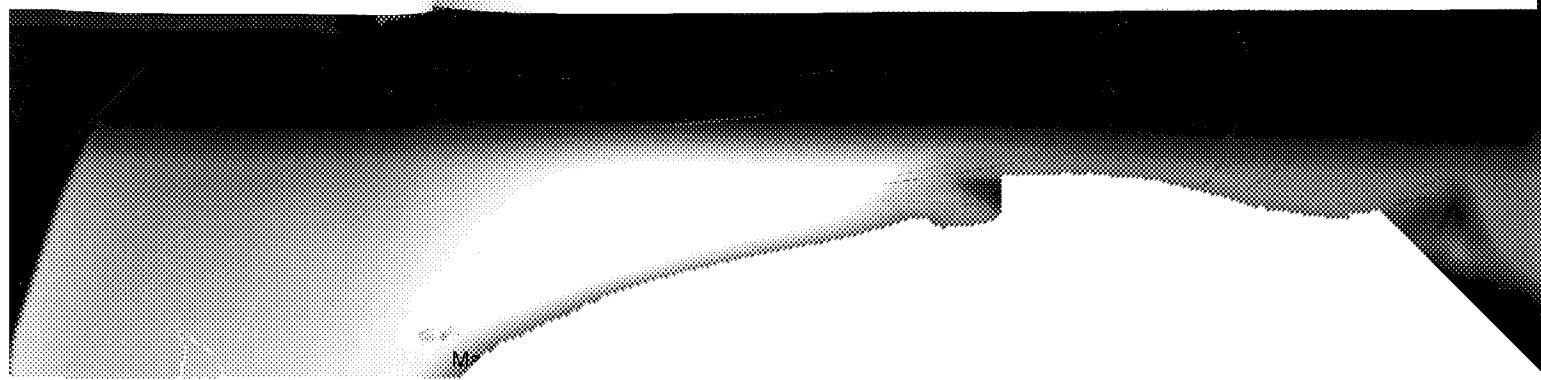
This x-ray film shows a chondroma of the rib.
